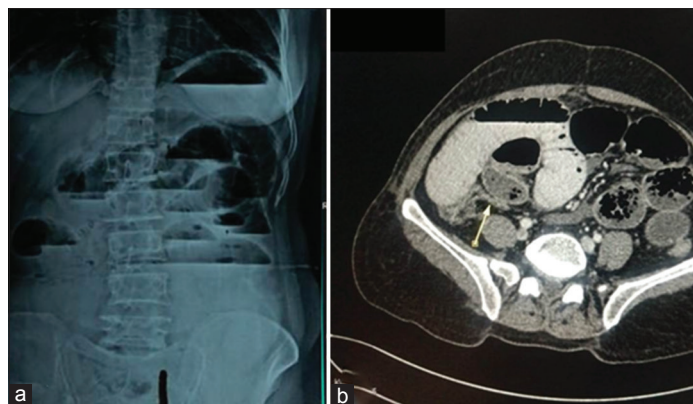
(a) X-ray erect abdomen showing multiple air-fluid levels; (b) contrast-enhanced computed tomography suggests small bowel obstruction in multiple levels
